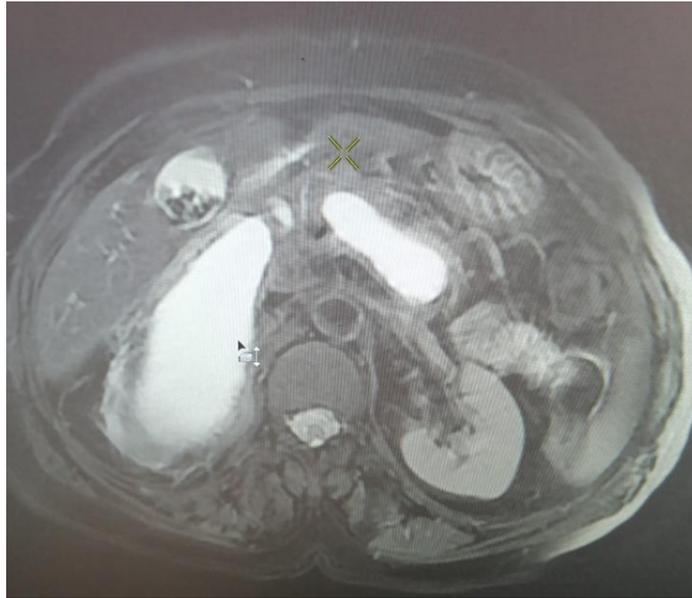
MRI showing a retropancreatic cystic formation
